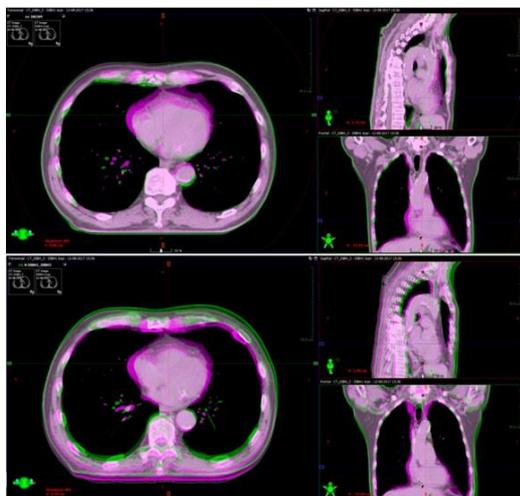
green/magenta overlay of 1<sup>st</sup> (green) and 3<sup>rd</sup> (magenta) DIBH CT in patient #44. Top panel: registration between DIBH1 and DIBH3, based on DICOM origin: bones are well aligned, no major differences in lung volume or thorax surface, but clearly extended heart volume anteriorly. Bottom panel: CT scans are registered on the heart (3<sup>rd</sup> DIBH CT shifted 0.9 mm to the right, 7.4mm shift posteriorly and 3 mm cranially). There is still clear difference in heart circumference on both scans, while it fits well in cranio-caudal direction. DIBH lung volume increased by 54% compared to FB.
